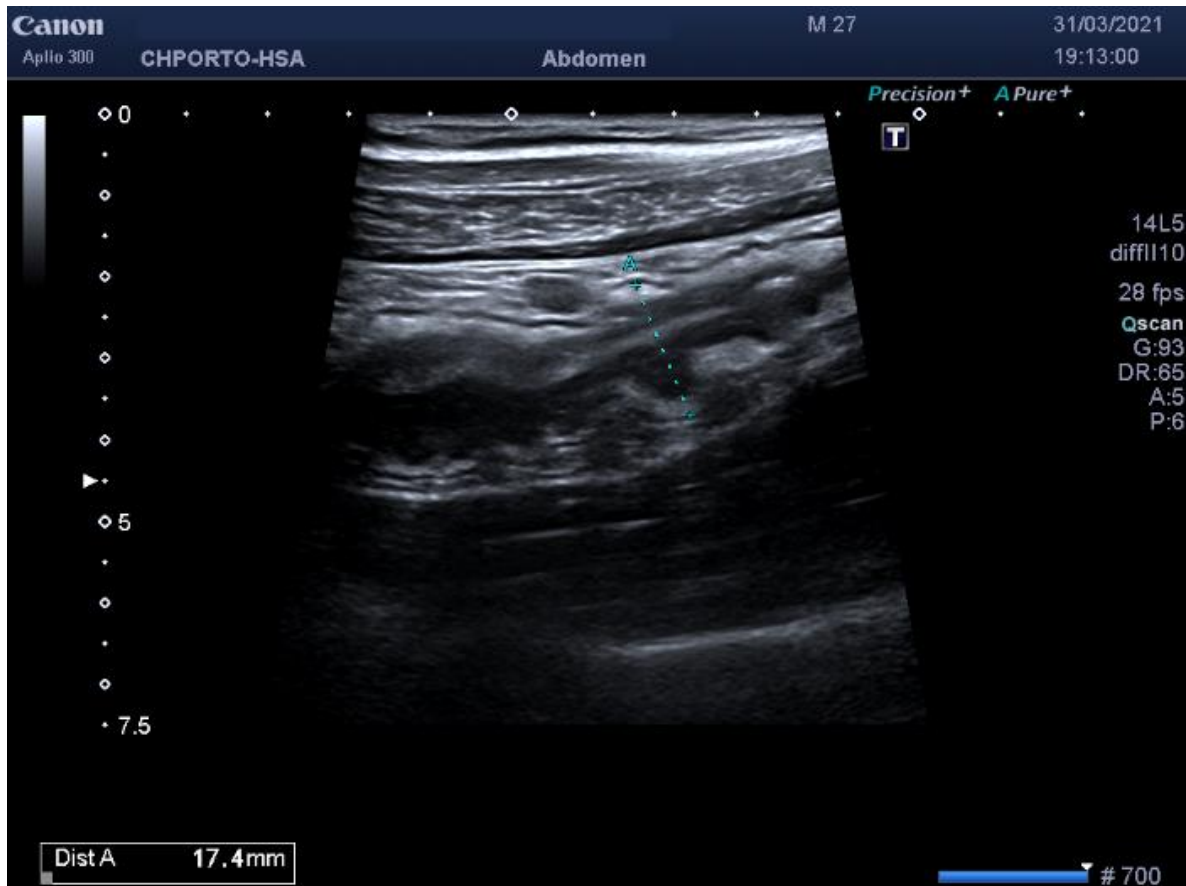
Abdominal ultrasound in the first exacerbation of Ulcerative Colitis from 31/03/2021
